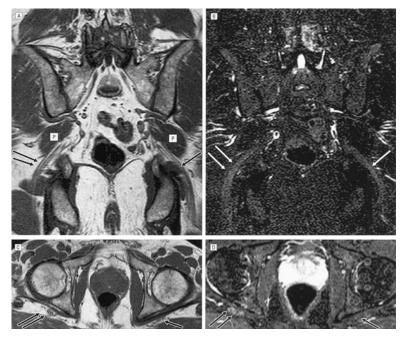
Coronal and axial T1-weighted (*A*, *C*) and short tau inversion recovery (STIR) (*B*, *D*) sequences through the lumbosacral plexus and sciatic nerves bilaterally. *A*, *C*, The anatomical T1-weighted sequences demonstrate the course of the sciatic nerves (*double* and *single arrows*) exiting the sciatic notch beneath the piriformis muscles (p). *B*, *D*, The STIR sequences demonstrate the right sciatic nerve (*double arrows*) to be larger and higher in signal compared with the left sciatic nerve (*single arrows*) as it exits the sciatic notch. Source: Lewis AM, Layzer R, et al. Magnetic resonance neurography in extraspinal sciatica. Arch Neurol 2006;63(10):1469-1472. Copyright © 2006, American Medical Association.
